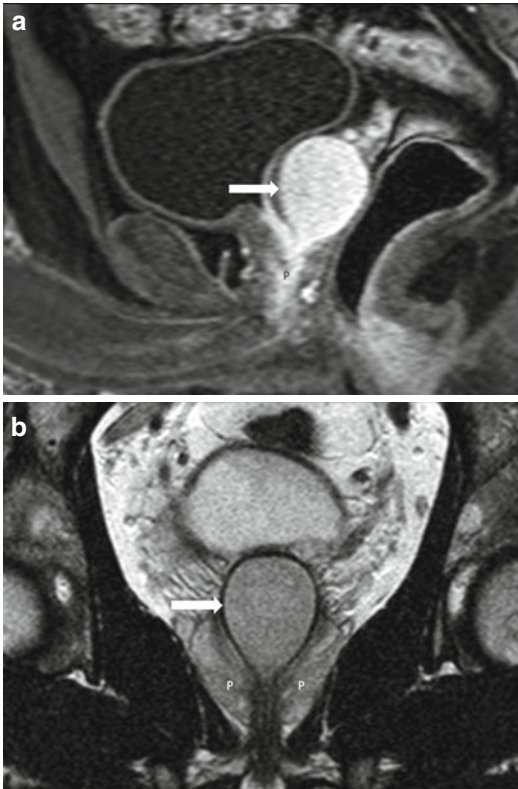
Mullerian duct cyst: sagittal T1-weighted, post-contrast (a), and coronal T2-weighted (b) MR images show a midline, large Mullerian duct cyst (arrows) arising from the verumontanum and extending above the prostate (p). The cyst does not enhance but has high signal intensity on the T1-weighted image because of hemorrhagic or proteinaceous content
